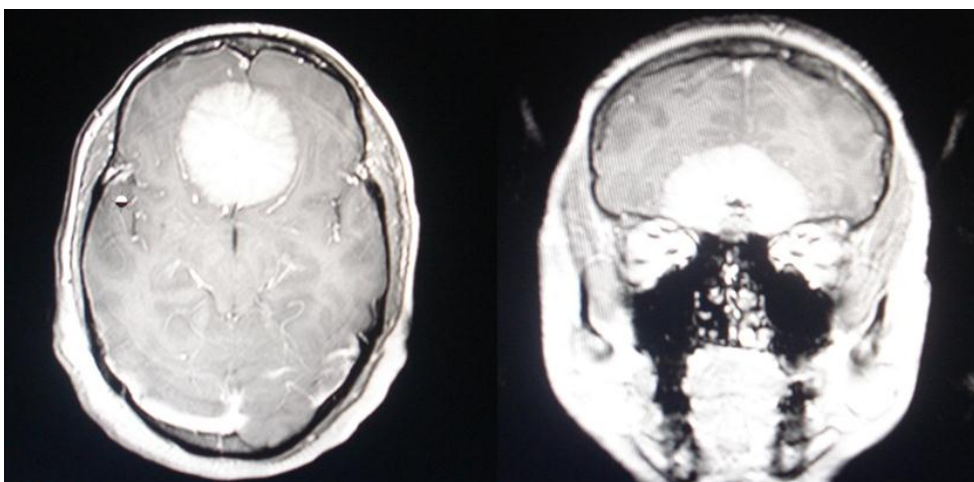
Pre operative MRI axial and coronal showing olfactory groove meningioma respectively.
